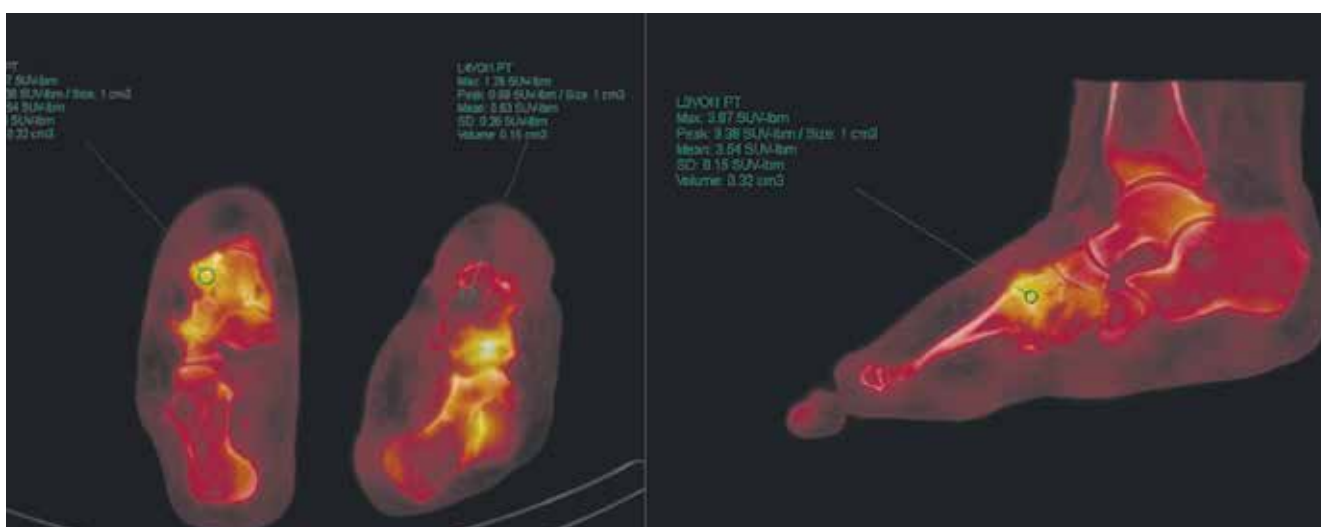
Patient N. – Charcot foot case: SPECT/CT images in axial and sagittal planes showing intense radiopharmaceutical hyperfixation (SUVlbm (max) = 3.87) in ankle joint, Lisfranc and Chopart joints on the left foot. Similar, but less intense radiopharmaceutical hyperfixation is seen in Lisfranc and Chopart joints on the right foot indicating aseptic inflammation
